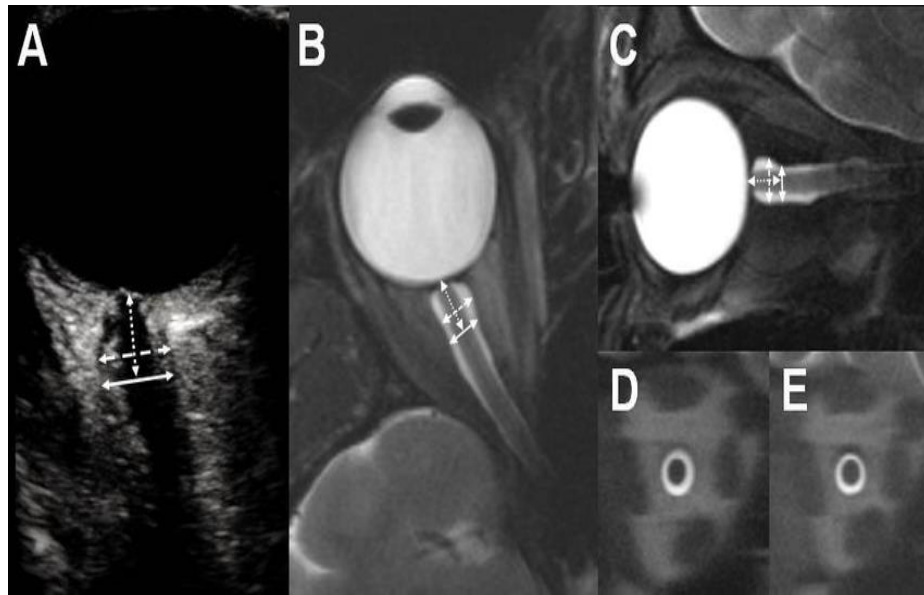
2. 24 Shows transbulbar sonography and MRI of the optic nerve sheath.
